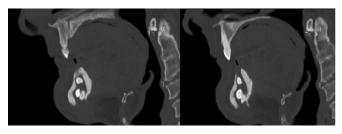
Sagittal sections of the CT images show the antero-posterior size of the ruptured cyst with impacted teeth
